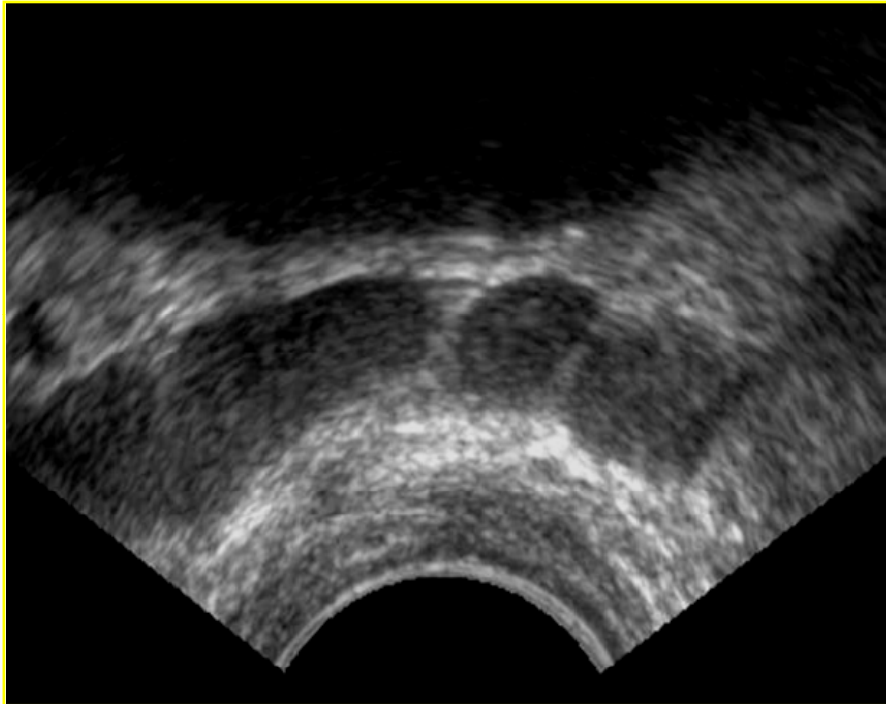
Zonal anatomy of the prostate. Transition zone and peripheral zone on (a) T2 magnetic resonance imaging and (b) ultrasound. AFS = anterior fibromuscular stroma; PZ = peripheral zone; TZ = transition zone.
